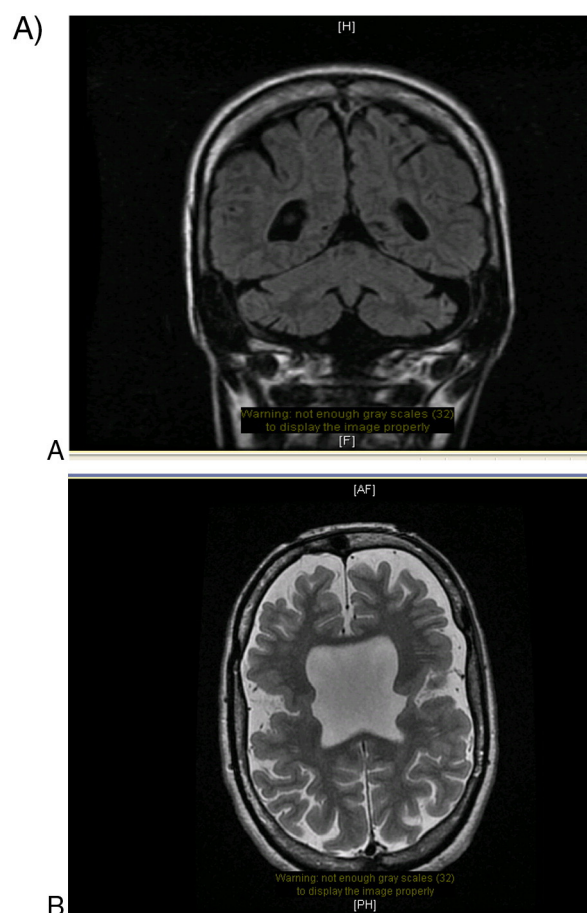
a: Axial FSE T2 and Coronal FLAIR images: In the frontal lobes, bilaterally there is open-lipped schizencephaly. The lip extends anterior from the precentral gyrus into the lateral ventricles bilaterally. No heterotopia was present. Pachygyria is noted anterior and posterior to the clefts bilaterally. b: EEG of the patient in Case 1 with bipolar montage demonstrates: The posterior background activity contains a 11-Hz alpha rhythm. Intermixed medium to medium-high amplitude 5-6 Hz bimodal and intermittent bursts of theta were present. Occasional semi-rhythmic 2 Hz bifrontally predominant diffuse 1-5 second runs of delta were present. A-Spikes: Principally during drowsiness and wakefulness, broad involving the F7-M1-T3 derivations. C-Seizure: Sudden muscle artifact, then rhythmic 3 Hz, later obscured by muscle artifact ending abruptly approximately 83 s after electrographic onset. Clinical onset preceded electrographic onset. Reword: Semiology involved the patient grabbing both knees first and then the hand rails, prior to elevating his right arm/flexed at the elbow prior to evolution to a generalized motor seizure with post-ictal somnolence. Patient grabs knees with hands, holds hand rail, then elevates right arm, flexed at elbow, then tonically slumps off bed with a secondary generalized seizure; sleeps postictally.
